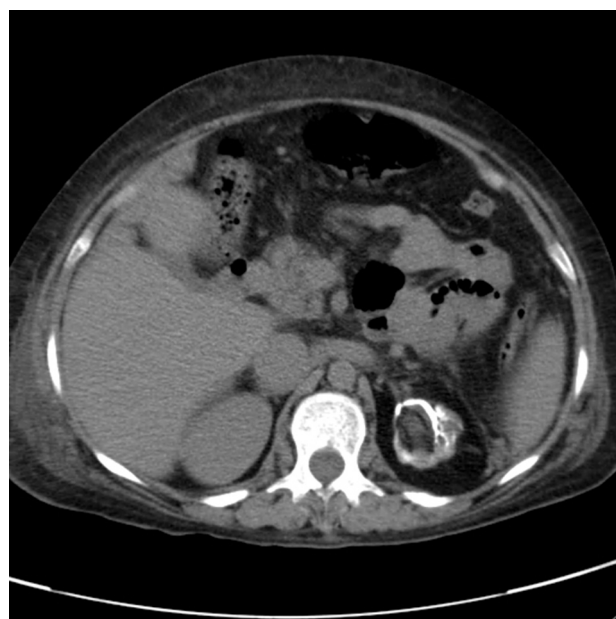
Postprocedure computed tomography scan of the abdomen showing a cast of glue in the mid-pole of the left renal artery.
